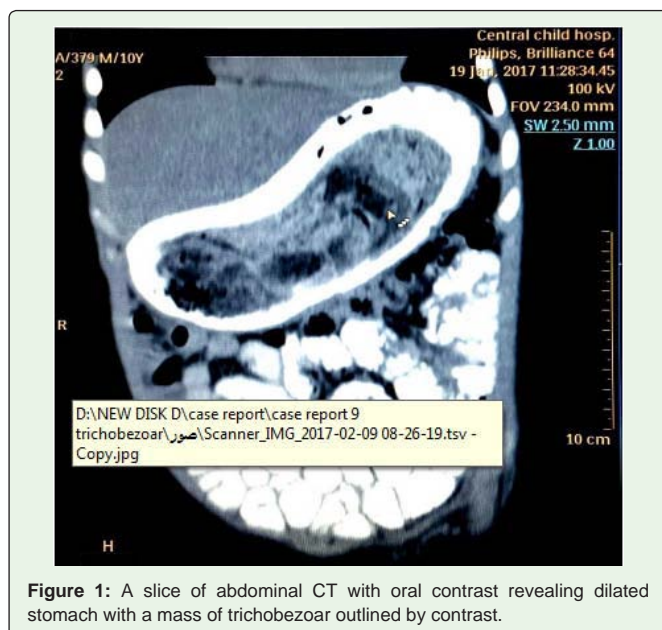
A slice of abdominal CT with oral contrast revealing dilated stomach with a mass of trichobezoar outlined by contrast.
